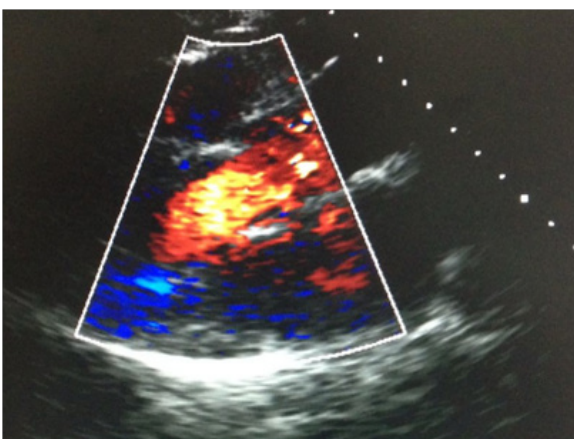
Transesophageal echocardiogram documented a massive regurgitating jet leading to severe aortic insufficiency.
